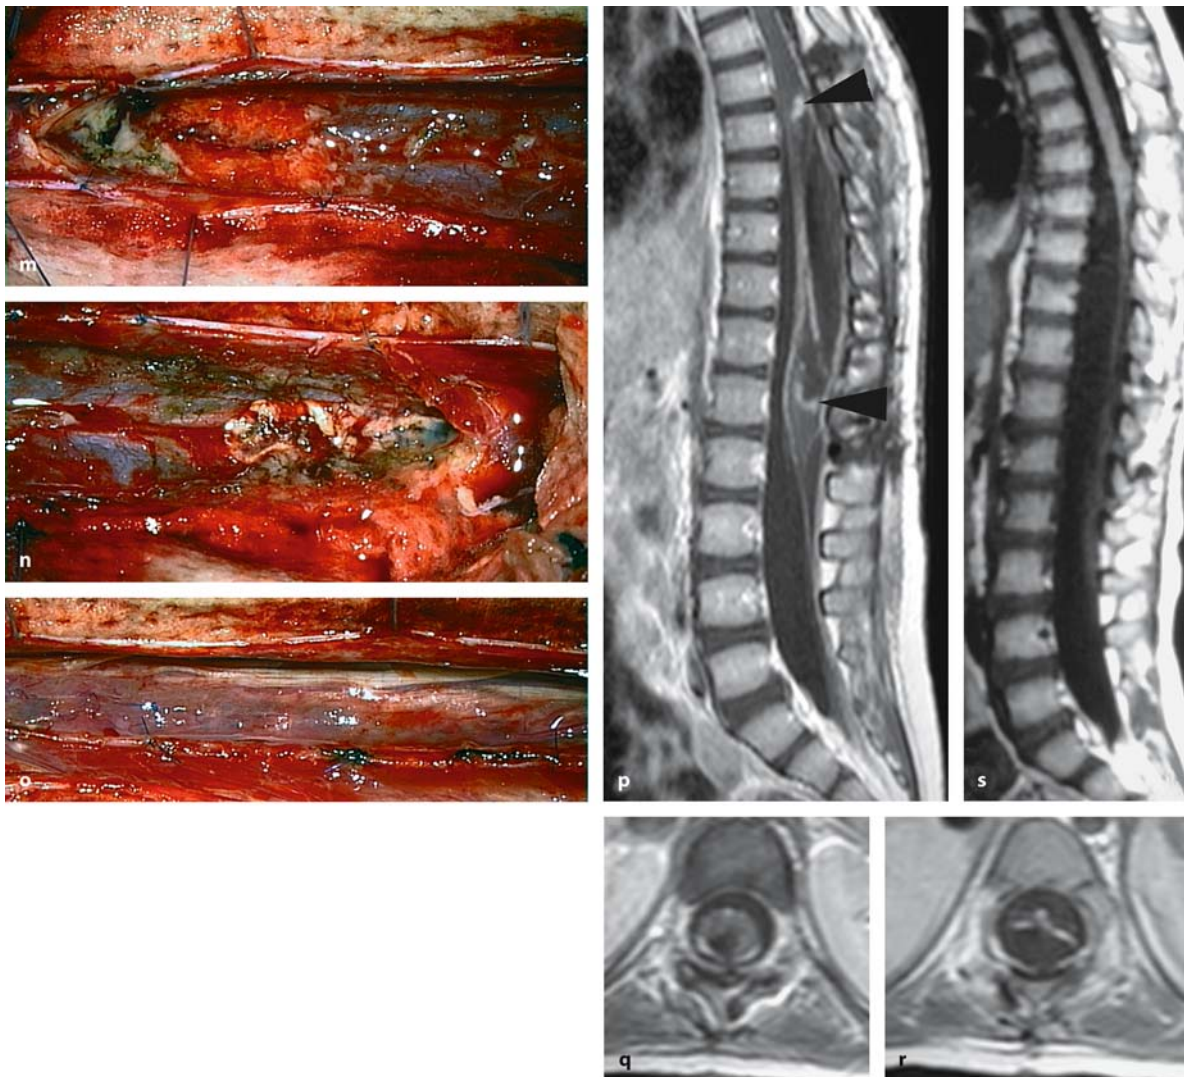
Sagittal T2- (a) and T1-weighted MRI images without (b) and with contrast (c), of an intramedullary astrocytoma WHO grade II–III at Th7–L2 in a 3-year-old girl with a 1-year history of a progressive paraparesis. There is irregular contrast enhancement and a marked enlargement of the cord. The spinal canal is widened. d The axial scan demonstrates a tumor with ill-defined margins. After opening of the dura and the arachnoid membrane, a grossly abnormal cord surface appears with arachnoid adhesions at the lower (e) and upper (f) tumor poles. g Opening the cord in the midline at the upper pole discloses the characteristic surface vessels converging
